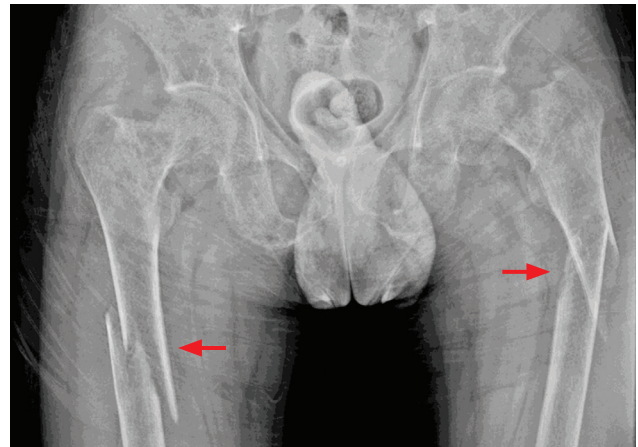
Frontal radiograph of both upper femurs shows badly displaced fractures of both upper femoral shafts (red arrows). These pathological fractures have occurred through bilateral underlying osteolytic lesions consistent with brown tumors.
